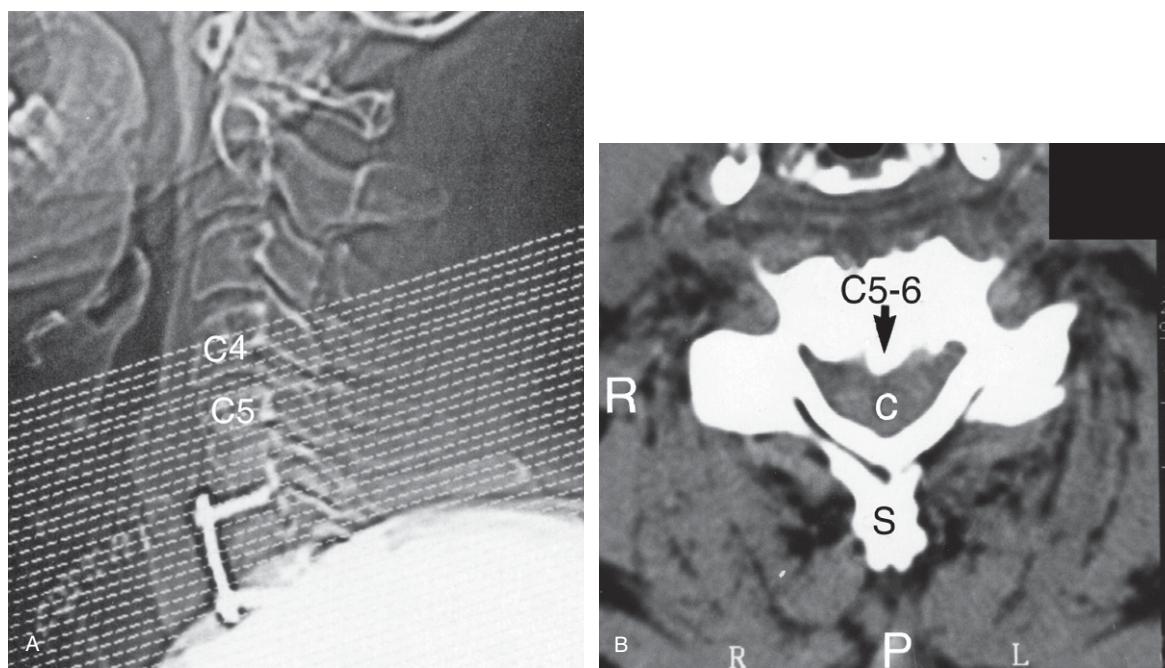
(A) CT cervical spine scout image. The anterior fixation plates extend from C6 to C7. (B) CT cervical spine axial image at the C5–6 level. Note the interbody fusion bony 'plug' (black arrow) still impinges upon the spinal cord anteriorly. C = spinal cord; P = posterior; S = spinous process.
